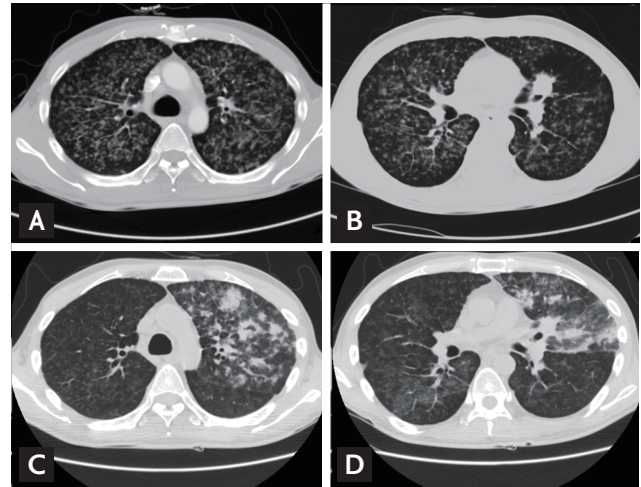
Chest computed tomography. (A, B) Initially multiple small nodules with a 2.3 cm pulmonary mass in the left lingular segment are seen. (C, D) On day 13 of gefitinib patchy ground-glass opacities and mass-like lesions with halo sign are shown, while the lung mass originally seen in the lingular segment has decreased in size.
